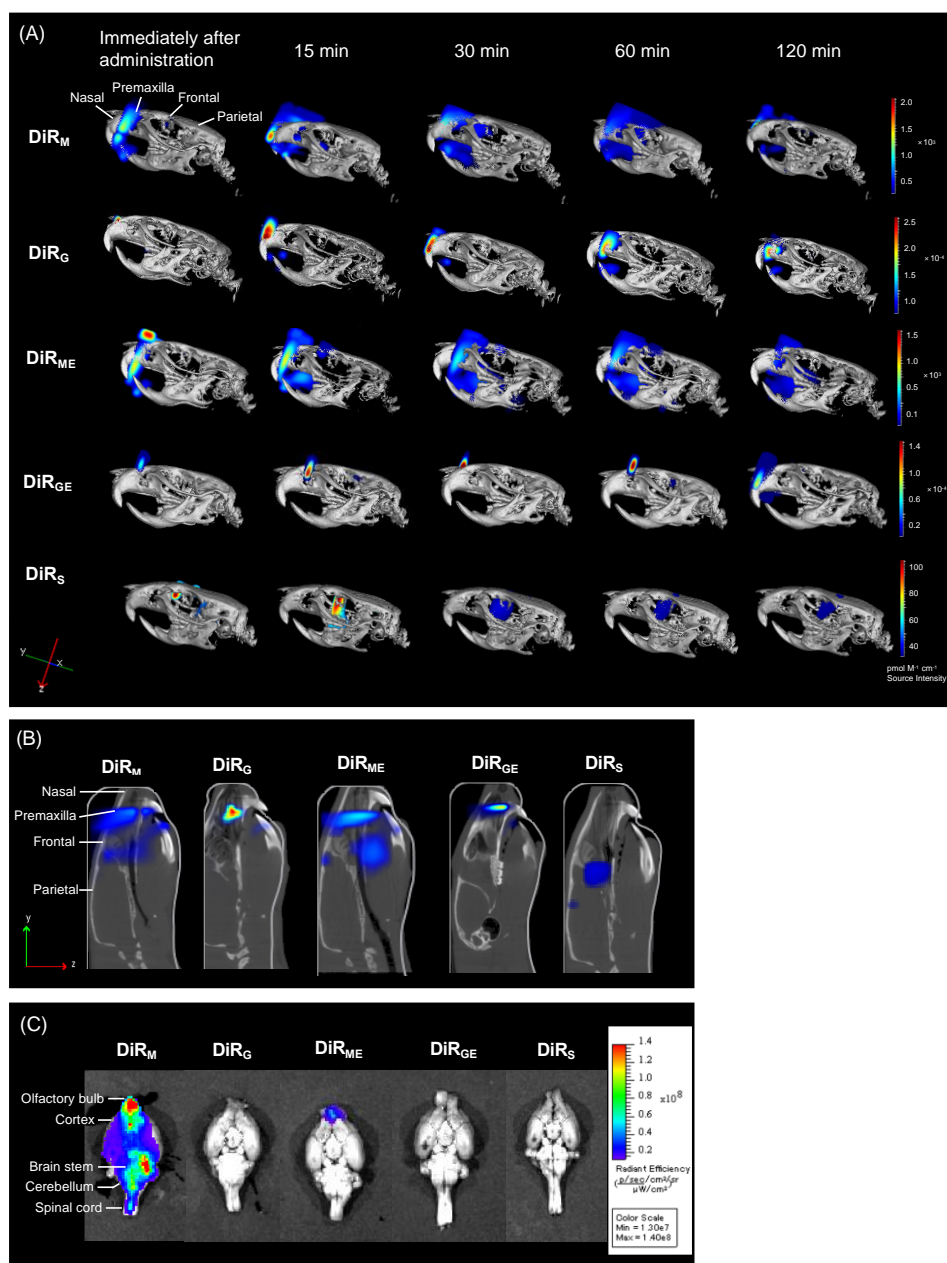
Biodistribution of LC formulations by *in vivo* fluorescent/ $\mu$ CT imaging. (A) *in vivo* fluorescent signals co-registered with X-ray and micro-computed tomography images ( $\mu$ CT); (B) Slice images in the lateral direction at 120 min post-administration; (C) *ex vivo* fluorescent images of whole brain at 120 min post-administration. Representative images are presented in this figure (n=3).
